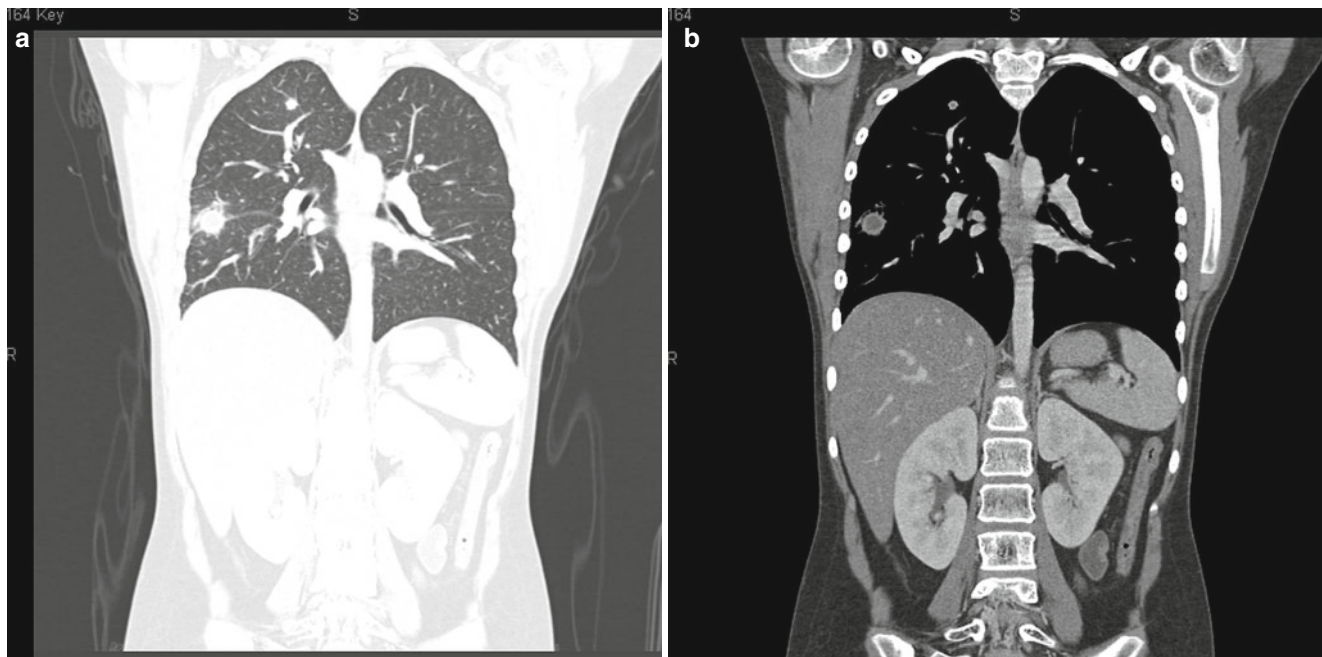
Aspergillus pneumonia. Ten-year-old girl with AML and biopsy proven aspergillosis. (a, b) The chest CT (shown with two different window views) demonstrates a 0.6 cm nodule in the right upper
